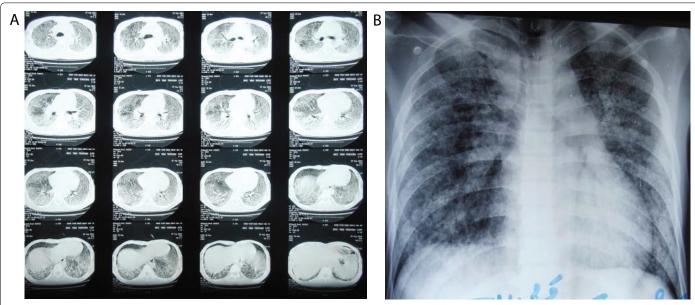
Chest CT image (A) and CXR films straight (B) of patient N.V.T.
